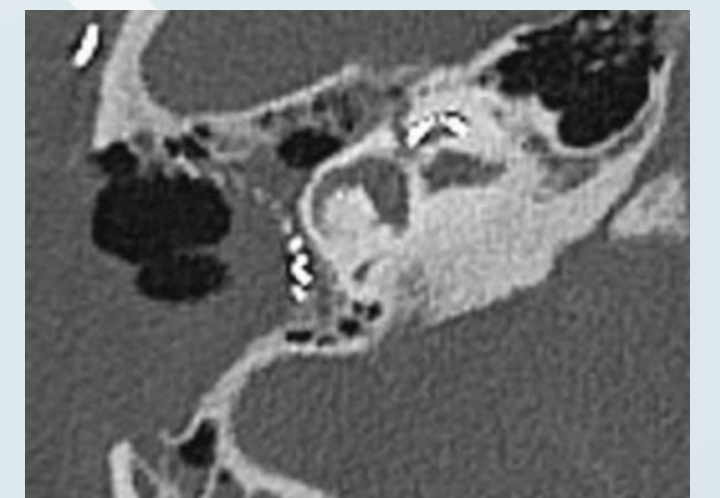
Correct electrode placement on post-operative CT
